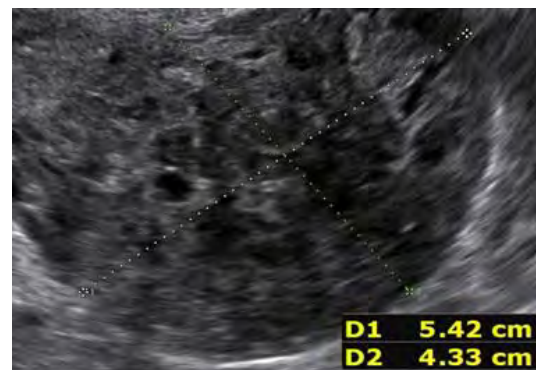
32-year-old patient in phase two prospective trial: Conventional ultrasound
